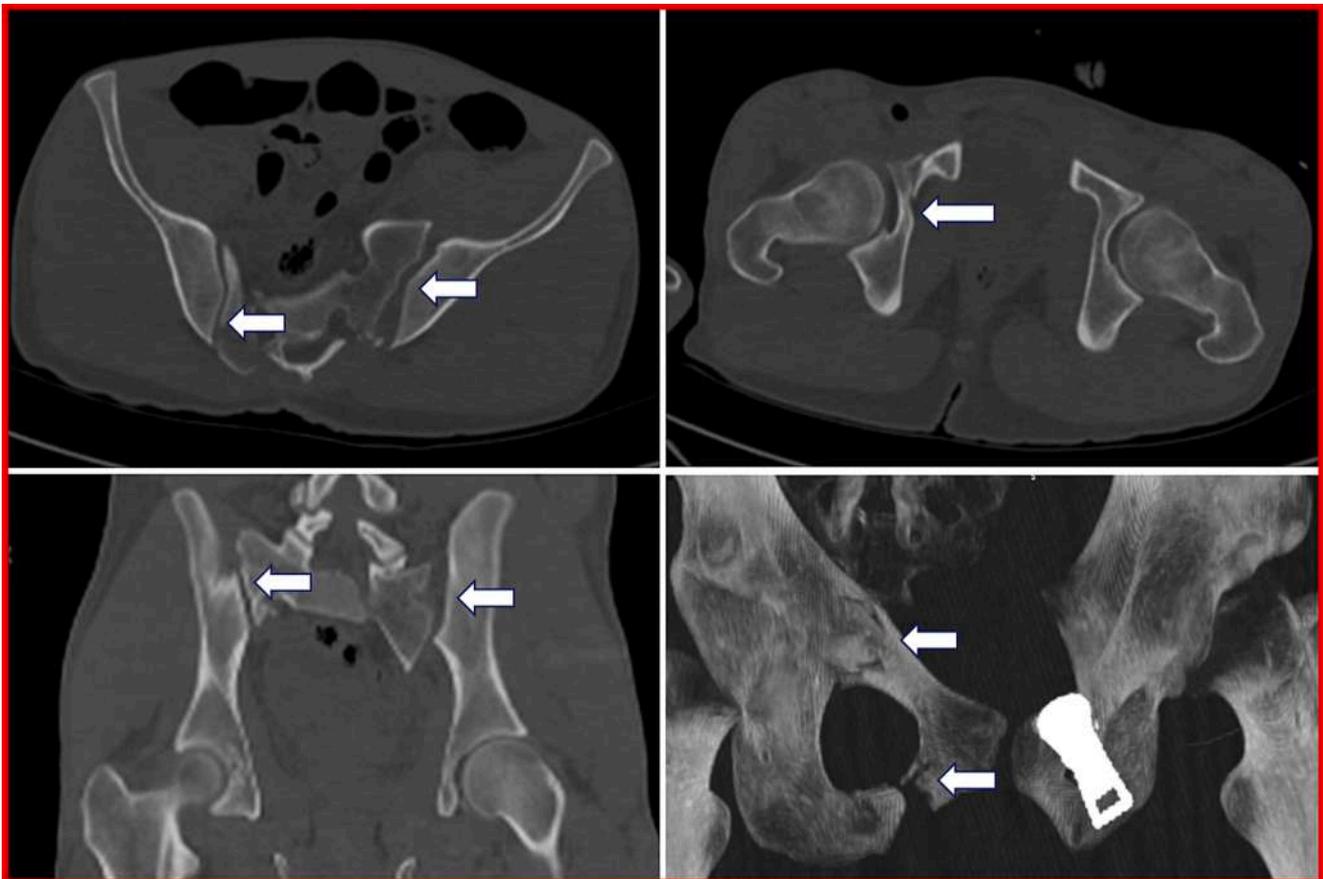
Multiple pelvic fractures on postmortem CT scan.
